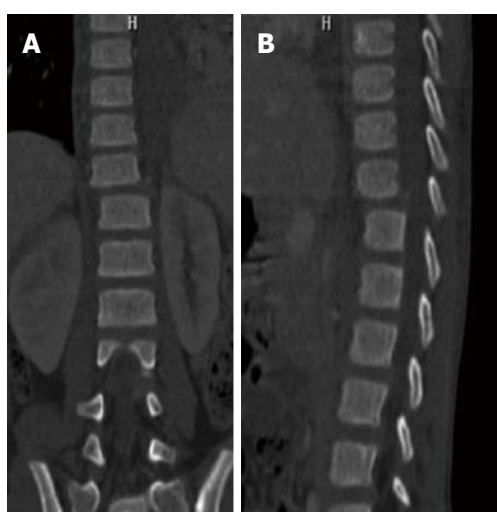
Type C2 rotational injuries. Coronal computed tomography (CT) image (A) and sagittal CT images (B) show C2 injury where rotation is superimposed on type B injury.
